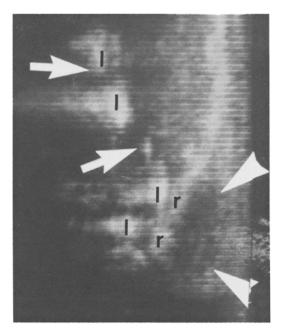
Case 4. Longitudinal ultrasound scan over the left midaxillary line. Extrathoracic soft tissue swelling is seen distally and laterally (arrow heads). Proximally pericostal edema and inwards displacement of lung echoes (arrows) are prominent (r=ribs; l=lung echoes)
